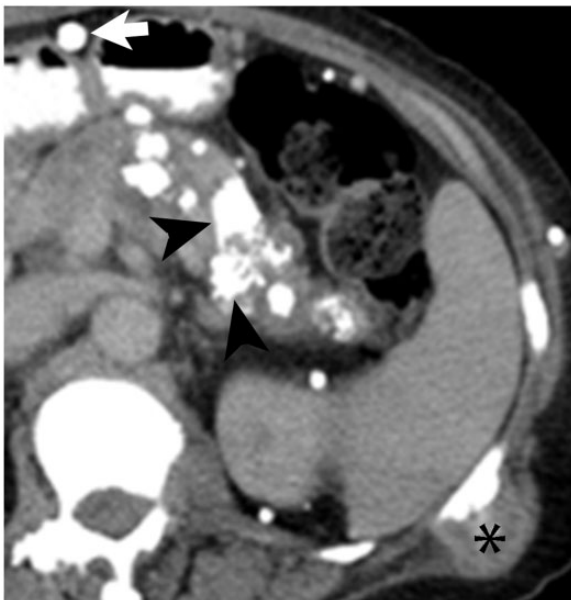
A 70-year-old woman with extraskeletal mesenchymal chondrosarcoma. Axial contrast-enhanced CT image demonstrates mineralized metastases in the pancreas (arrowheads) and lymph nodes (arrow). Diffuse skeletal metastases involving the vertebrae and ribs are also seen (asterisk).
